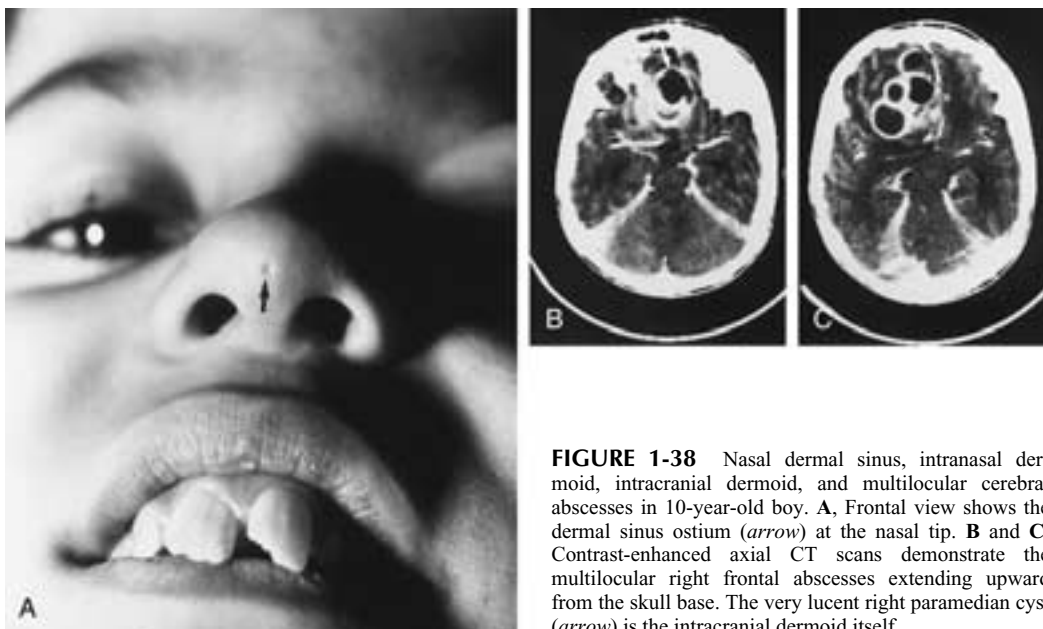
Nasal dermal sinus, intranasal dermoid, intracranial dermoid, and multilocular cerebral abscesses in 10-year-old boy. A, Frontal view shows the dermal sinus ostium (arrow) at the nasal tip. B and C, Contrast-enhanced axial CT scans demonstrate the multilocular right frontal abscesses extending upward from the skull base. The very lucent right paramedian cyst (arrow) is the intracranial dermoid itself.
